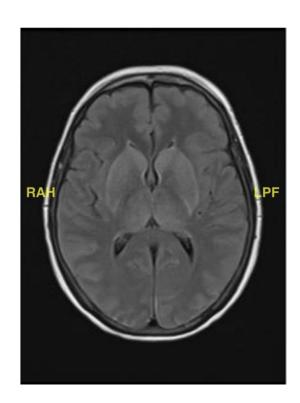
POD#1: MRI brain without contrast. Axial view. Increased signal with enlargement through the basal ganglia surrounded by a hyperintense rim delineating the lentiform nucleus.
